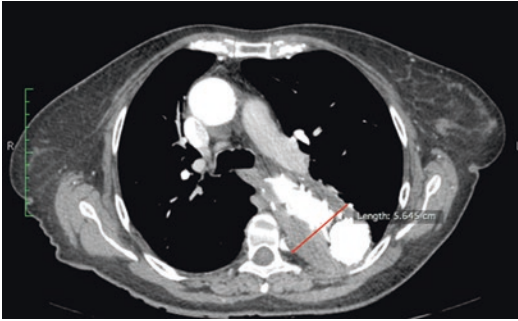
Postoperative CT angiography (3 months). Cross section showing the absence of endoleak and a slight decrease of the maximum transverse diameter of the thoracic aorta (5.6 cm) at the same point in Fig. 2
